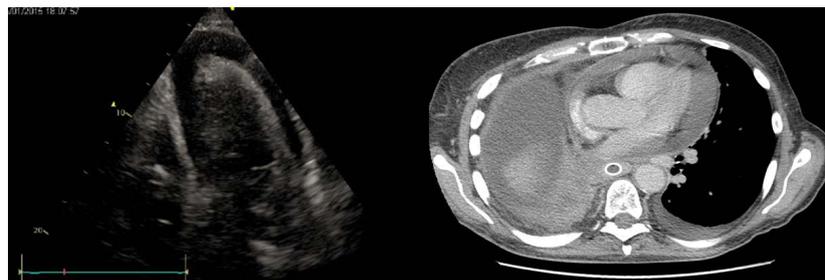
Echocardiogram and thoracic CT showing massive pericardial effusion.
